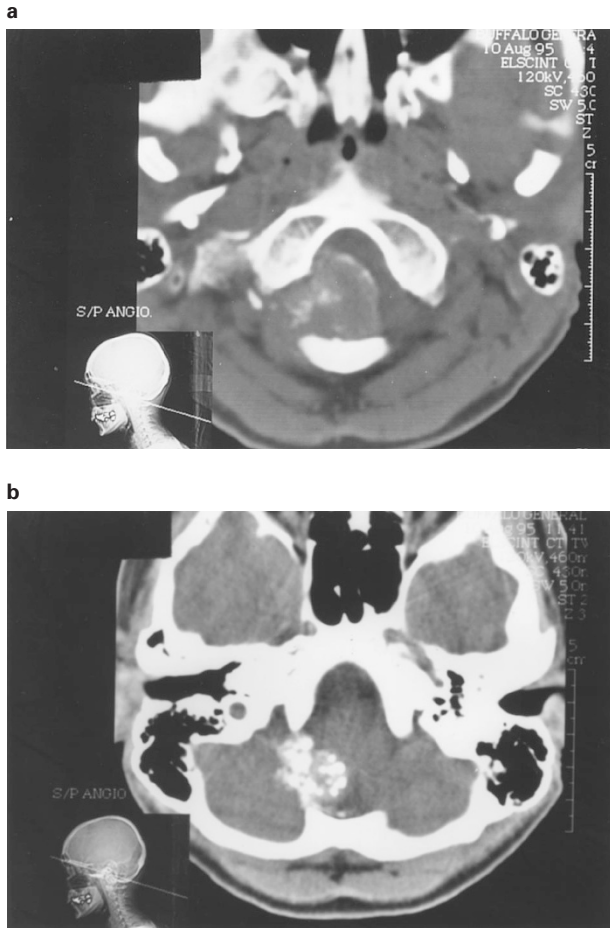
(A) CT scan at foramen magnum with enhancement: Large calcified tumor occupying greater part of foramen, primarily right side. (B) CT scan above foramen magnum: primarily calcified portion of tumor extending into right posterior fossa
